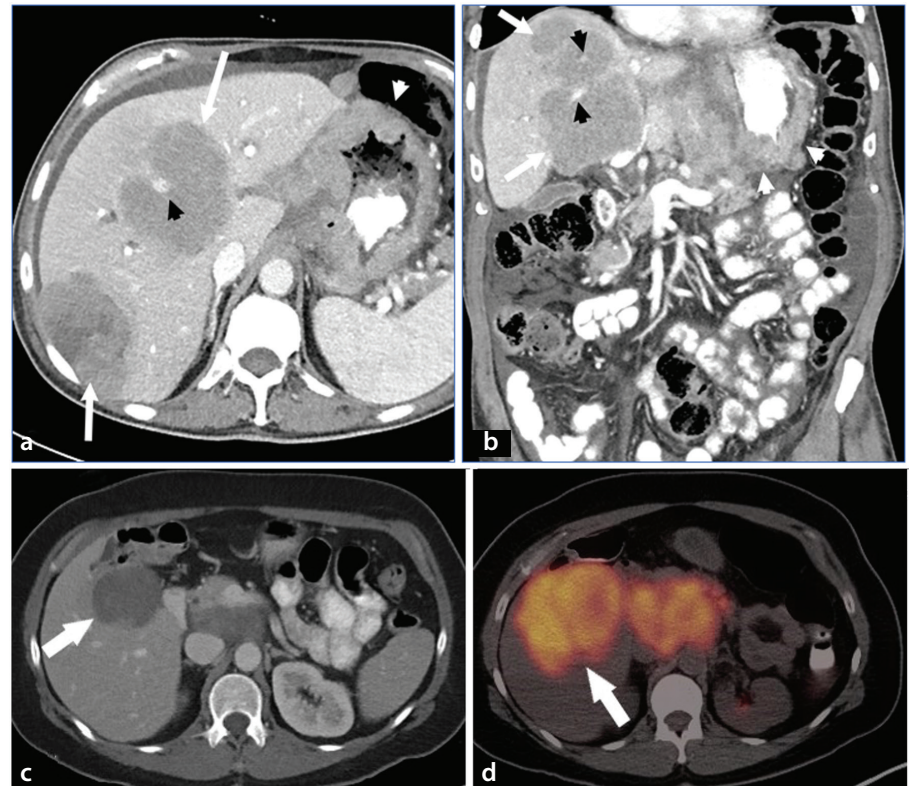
Hepatic lymphoma encasing vessels. Axial (a) and coronal (b) contrast-enhanced computed tomography (CT) shows multiple liver masses (long white arrows) and diffuse gastric wall thickening (short white arrows). As with lymphoma in other parts of the body, hepatic lymphoma tends to encase, rather than occlude, vascular structures. In this case, liver masses appear to encase branches of the portal vein (short black arrows). A companion case demonstrates a contrast enhanced CT scan (c) with a hypoattenuating lymphoma that is markedly fluorodeoxyglucose (FDG) avid on ¹⁸F-FDG-positron emission tomography/CT scan (d) (white arrows).
